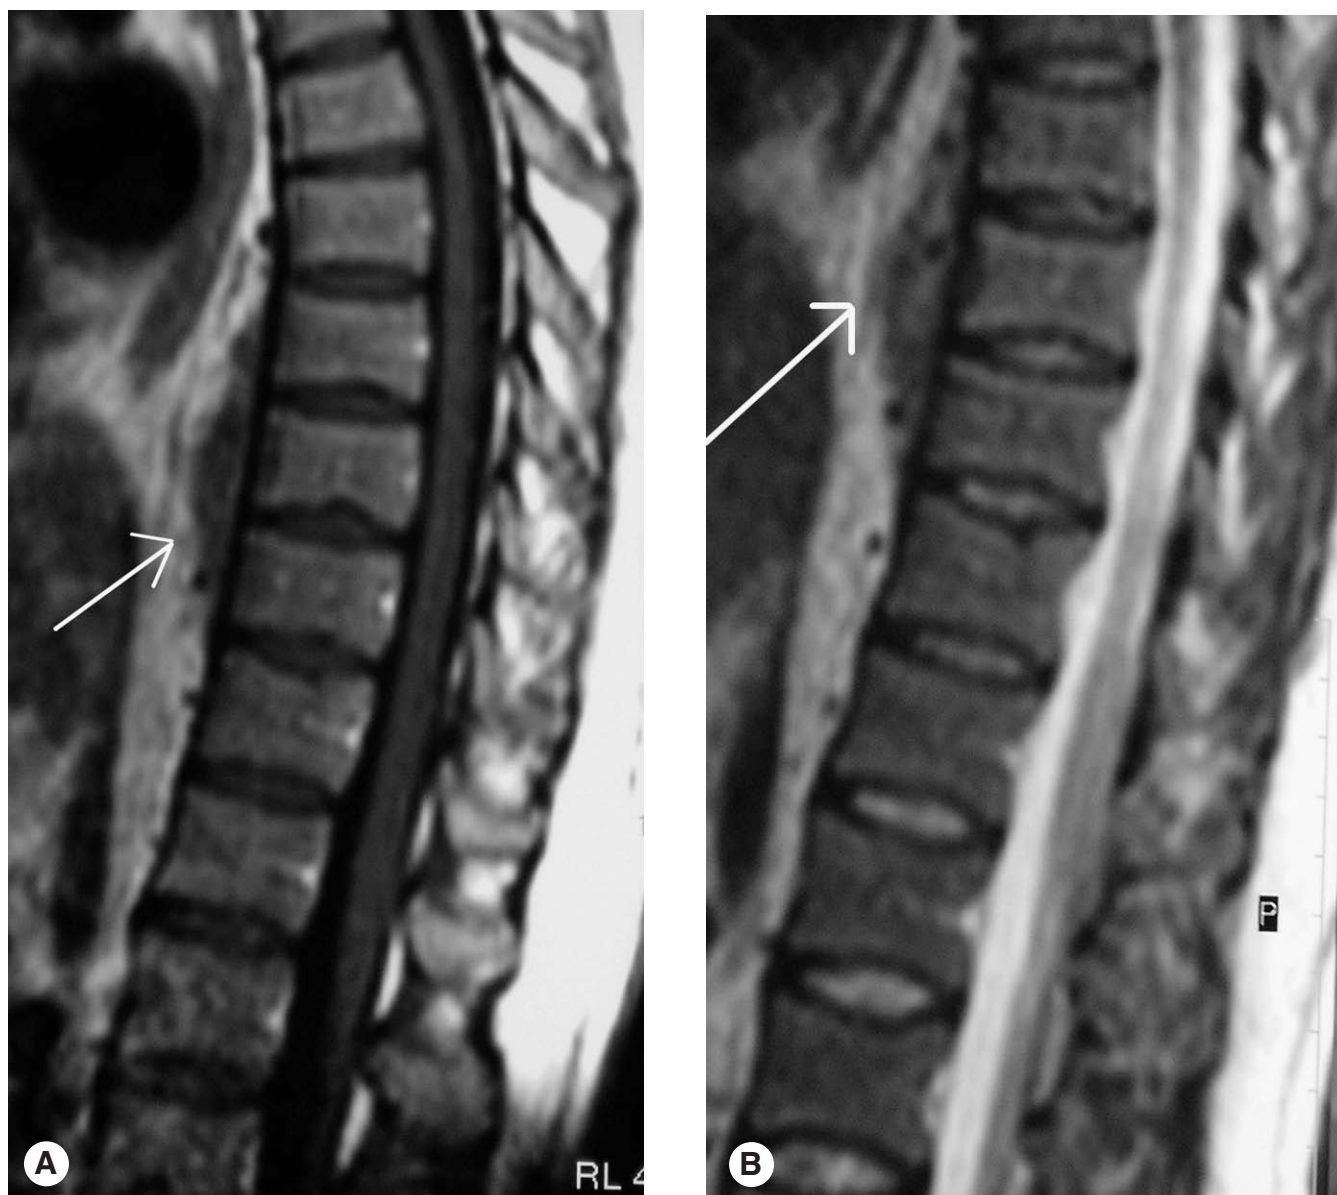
Sagittal T1 (A) and T2 weighted (B) MR images of the thoracic spine show a fusiform soft-tissue prevertebral mass (arrow) extending from the level of T8 to T10.
